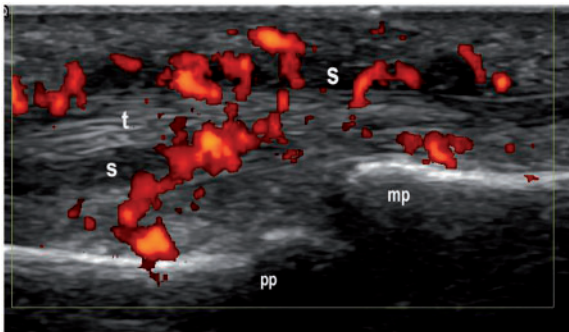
Longitudinal US image with PD mode of a finger tenosynovitis. Hypoechoic thickening of the synovial sheath (s) that surrounds the tendon (t) and pathological Doppler signal within the synovial sheath and the tendon are seen. pp: proximal phalanx; mp: middle phalanx.
